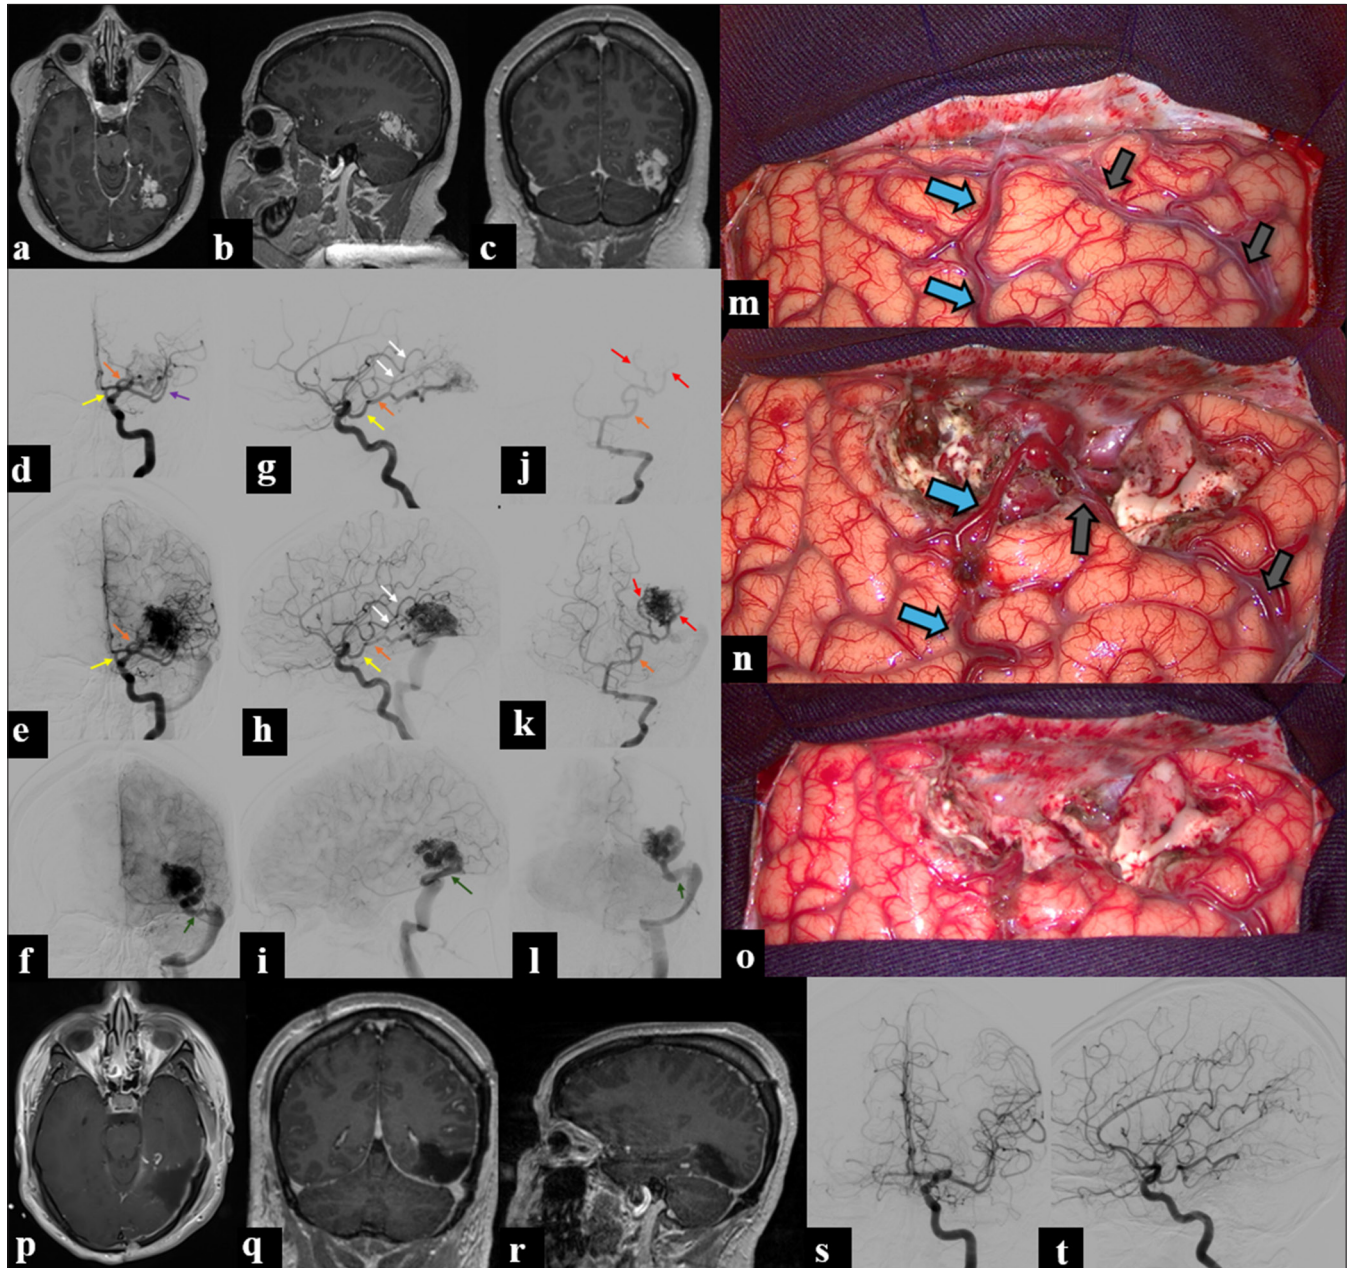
(a) Axial view of the post-contrast T1-weighted sequence of MRI revealing an AVM at the fusiform gyrus. (b and c) Sagittal view (in b) and coronal view (in c) demonstrating that the AVM presents a relationship with the tentorium. (d) Anteroposterior view of the early arterial phase of the angiogram of the left internal carotid artery revealing that the main feeding arteries were branches of the middle cerebral artery (pointed by the purple arrow) and the posterior cerebral artery (pointed by the orange arrow). The yellow arrow points to the posterior communicating artery. (e) Late arterial phase of the anteroposterior view demonstrating the nidus. The yellow and orange arrows point to the posterior communicating artery and to the posterior cerebral artery, respectively. (f) Venous phase demonstrating the main draining vein (pointed by the green arrow), with signs of venous hypertension such as a reduction of its caliber before draining into the transverse-sigmoid junction. (g and h) Lateral view of the arterial phase of the angiogram of the left internal carotid artery revealing that the feeders were the temporal branches of the middle cerebral artery (pointed by white arrows) and branches of the posterior cerebral artery, which was pointed by the orange arrow. The posterior communicating artery is pointed, as well, by the yellow arrow. (i) Venous phase of the lateral view showing the main draining vein, pointed by the green arrow, draining to the sigmoid-transverse junction. (j and k) Arterial phase of the anteroposterior view of the vertebrobasilar angiogram demonstrating the lateral posterior chorooidal arteries (pointed by the red arrows), the main feeders from the posterior cerebral artery (pointed by the orange arrow). (l) Venous phase of the anteroposterior view of the vertebrobasilar angiogram demonstrating the main draining vein (pointed by the green arrow). (m) Initial aspect before the resection of the inferior temporal gyrus. The vein of Labbé (blue arrow), which in this case is part of the venous drainage of the AVM, and another superficial draining vein (gray arrow), tributary to the superficial middle cerebral vein, are demonstrated. (n) Aspect after the resection of the inferior temporal gyrus, enabling the visualization of the AVM nidus. The vein of Labbé (blue arrow) and the other superficial draining vein (gray arrow) are demonstrated, as well. (o) Final aspect, after the excision of the AVM. (p-r) Axial (p), coronal (q), and sagittal views (r) of the postoperative MRI post-contrast T1-weighted sequence showing the surgical cavity with the removal of the entire lesion. (s and t) Anteroposterior view (s) and lateral view (t) of the postoperative angiogram revealing the absence of the early draining vein and the nidus.
